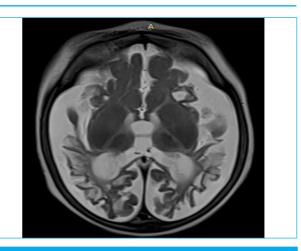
Axial T2 MRI shows atrophy of bilateral occipital lobes along with loss of white matter. Bilateral basal ganglia are spared (shown by white arrow)
